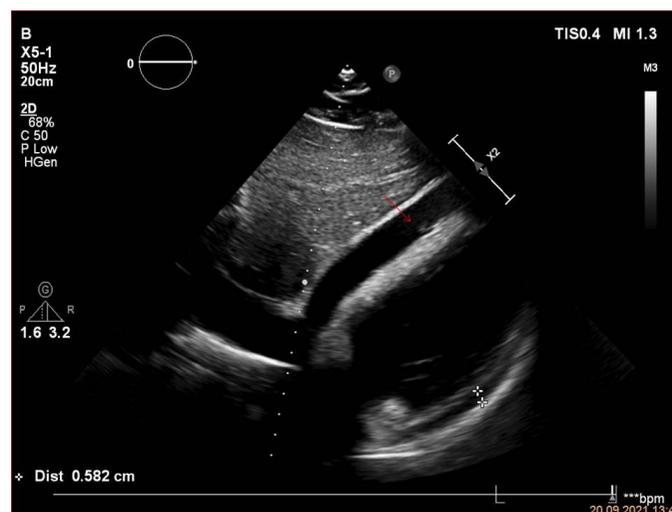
Foreign body in the right ventricle and its acoustic shadow are seen in the area marked with the arrow in the transthoracic echocardiography image
